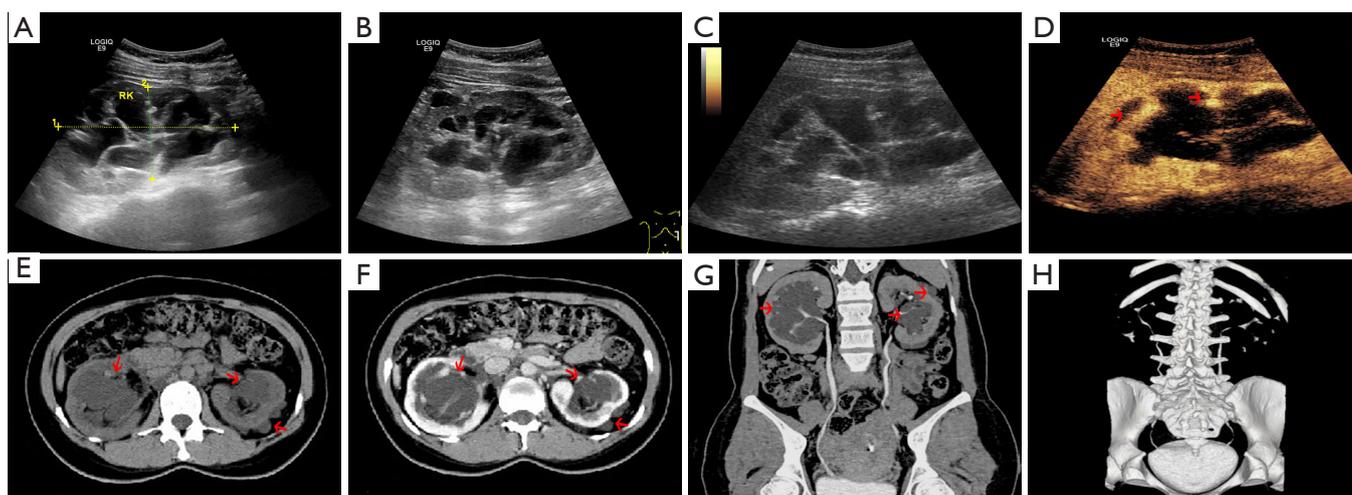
A 37-year-old female (patient B) with known renal lymphangioma (case 2). (A,B) A multilocular cystic area resembling hydronephrosis was found in the renal sinus, with a fine wall and slight thickening in some areas. The renal cortex was locally thin in both kidneys. (C,D) CEUS appearance of renal lymphangioma: the capsule walls and septa are filled with contrast agent (arrows). (E) CT plain scan showing cystic dilatation in the renal pelvis of both kidneys and around the left kidney (arrows). (F) Enhanced CT showing a small amount of fluid around the left kidney and bilateral hydronephrosis (arrows). (G,H) CT urography showing a small amount of fluid around the left kidney (arrows); distortion of renal calyces due to the cystic change of renal sinus. RK, right kidney; CEUS, contrast-enhanced ultrasound; CT, computed tomography.
